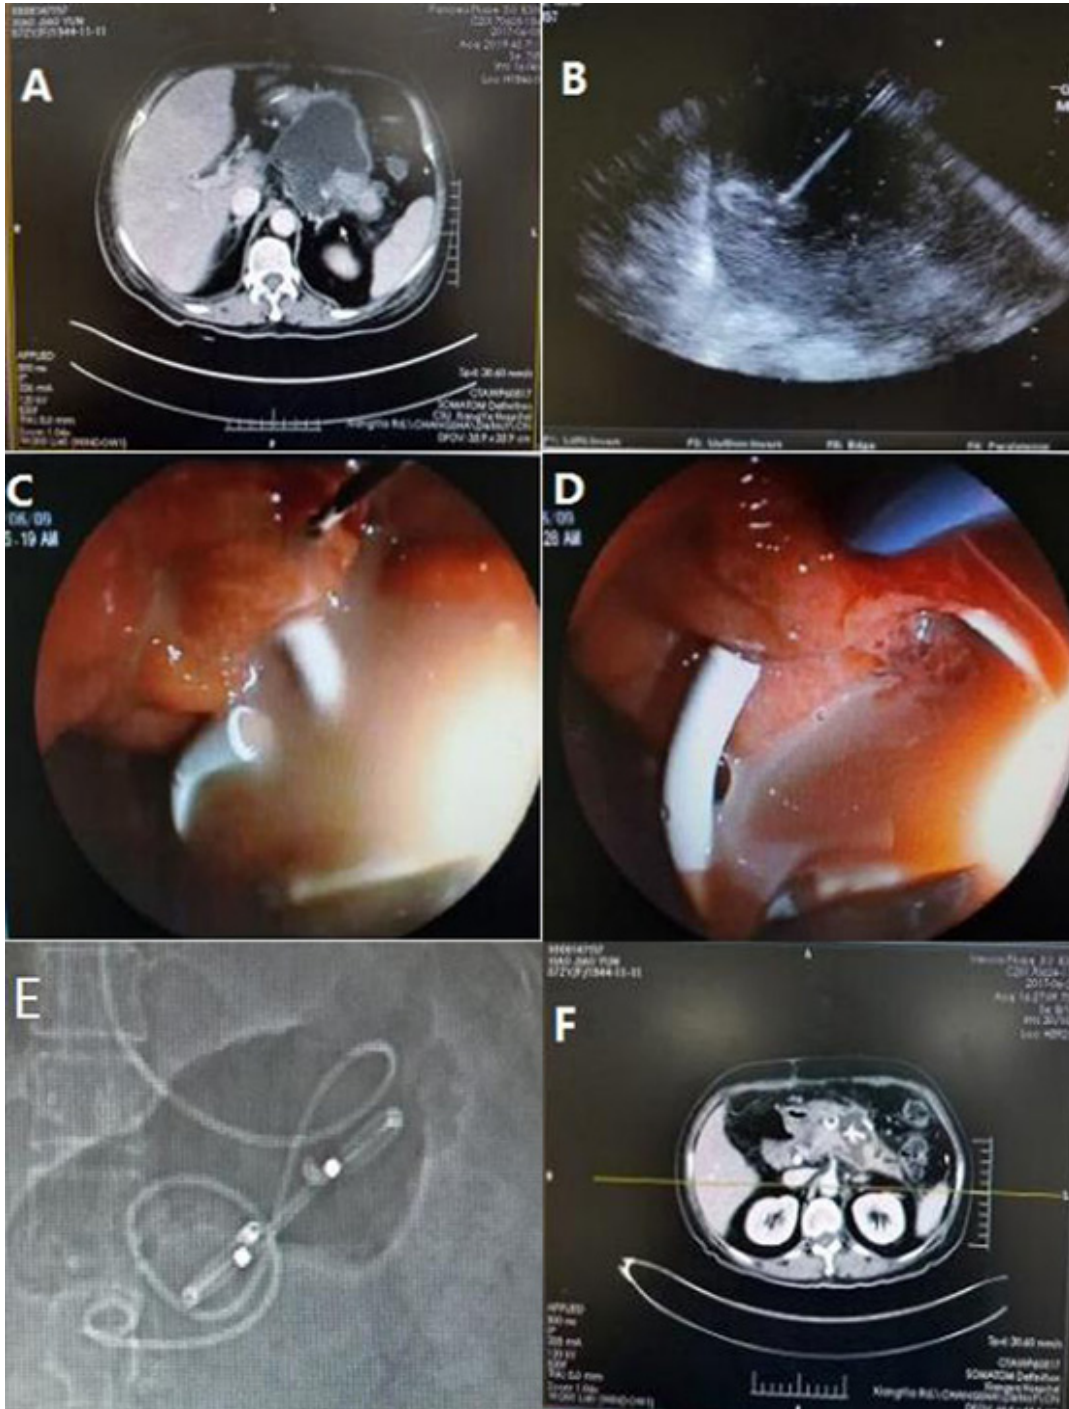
A Female Patient with An Infected Pancreatic Pseudocyst Was Deployed with Double Pigtail Stent and Nasocystic Tube. A: CT Scan Photo Showing the Pancreatic Pseudocyst. B: Endoscopic Ultrasound Guiding the Transluminal Draining Procedure. C: A Double Pigtail Stent Being Deployed in The Pancreatic Infected Pseudocyst. D: A Nasocystic Tube Combined A Double Pigtail Stent Being Deployed in The Pancreatic Infected Pseudocyst. E: Radiograph Showing A Double Pigtail Stent and A Nasocystic Tube in The Pancreatic Pseudocyst. F: CT Scan Photo Showing Resolution of The Pancreatic Pseudocyst.
